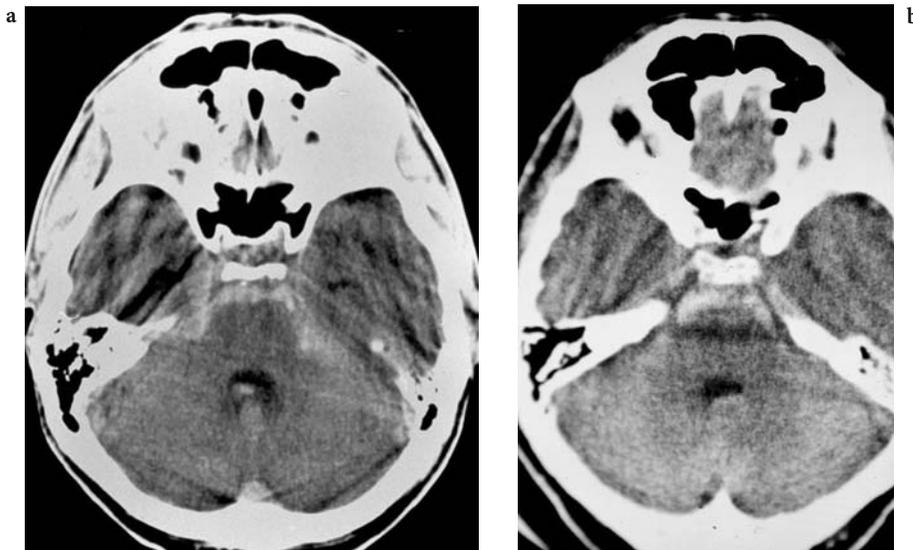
Typical perimesencephalic hemorrhage on CT scan
